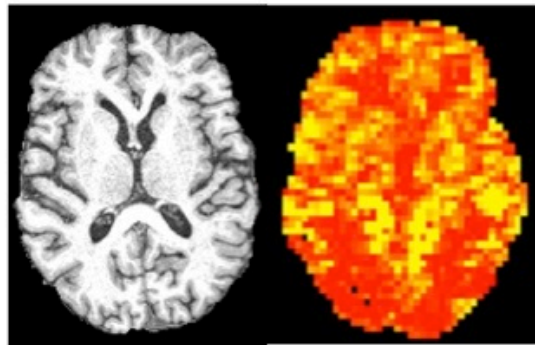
Axial slices of high-resolution T1-weighted brain and ASL derived cerebral blood flow map used for cerebral perfusion measurements (mL/100g/min).
